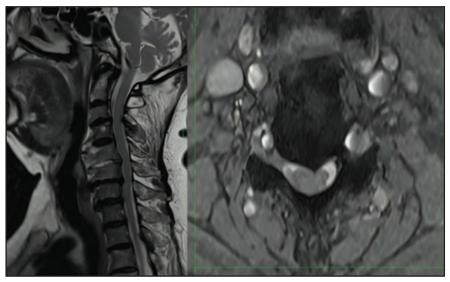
MRI depicting sagittal and axial (C5/C6 level) views of the cervical spine, revealing C5/C6 discitis, vertebral body edema (anterior), and a small paravertebral collection without epidural abscess formation
